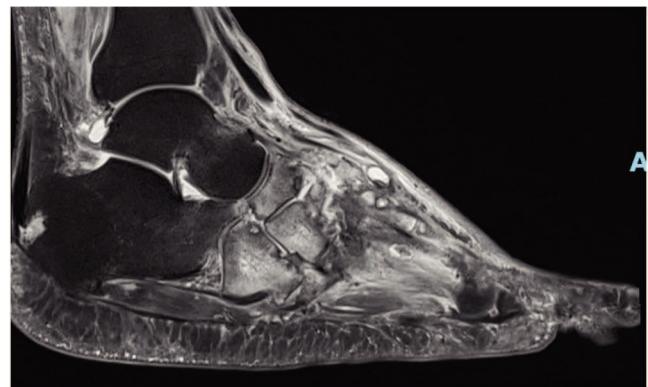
Magnetic resonance imaging demonstrating diffuse bone marrow oedema present within the navicular, all cuneiforms, cuboid and bases of all metatarsals suggestive of Charcot foot.
